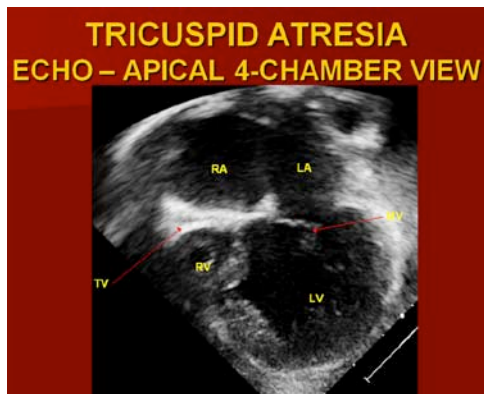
Apical four-chamber 2-dimensional echocardiographic view of an infant with tricuspid atresia showing enlarged left ventricle (LV), a very small right ventricle (RV), and a dense band of echoes at the site where the tricuspid valve echo should be (TV). Partially open mitral valve (MV) is also seen. Note the attachment of the anterior leaflet of the detectable atrio-ventricular valve to the left side of the interatrial septum. LA, Left atrium; RA, Right atrium.
